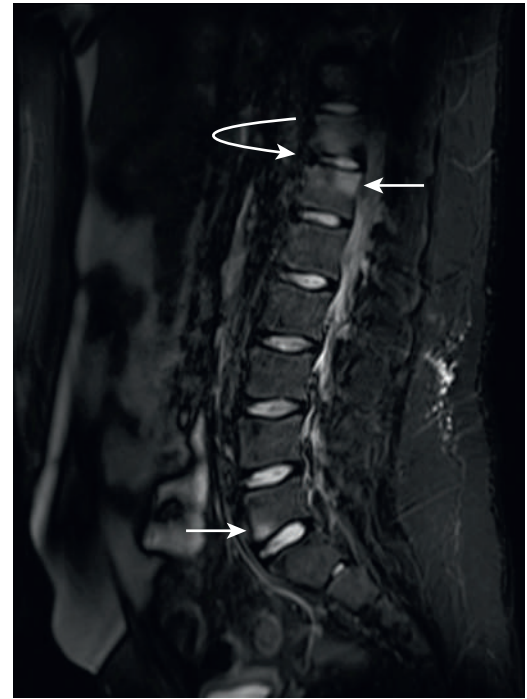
Short T1 inversion recovery image from whole body MRI of a 15-yr-old boy with HLA-B27-negative JSpA. The MRI shows active corner inflammatory lesions of vertebral end plates at multiple levels (straight arrows) and more chronic-appearing discovertebral unit changes (curved arrow). (From Srinivasalu H, Sikora KA, Colbert RA. Recent updates in juvenile spondyloarthritis. *Rheum Dis Clin N Am.* 2021;47:565–583, Fig. 7, p. 574.)
